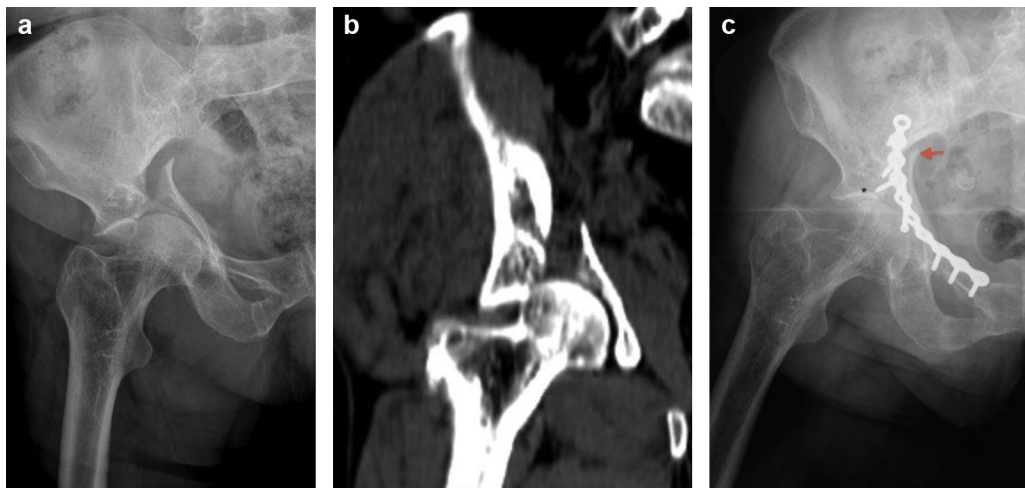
a and b: preoperative radiograph and CT-scan of a patient undergoing the modified Stoppa approach to treat a transverse fracture. c: postoperative radiograph showing incomplete reduction (arrow) and incomplete correction of congruency (*).
